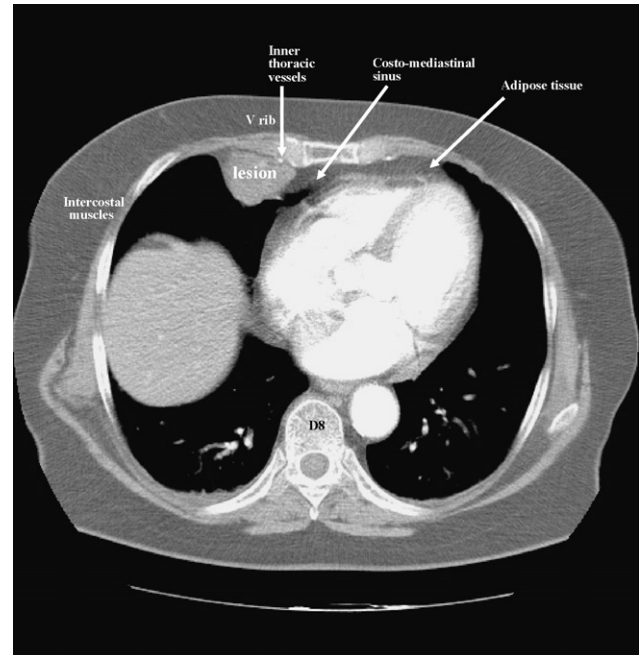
Leiomyosarcoma of the endothoracic fascia. Contrast-enhanced CT shows a mass with density characteristics indicating a soft bulky tissue. This mass is located at the level of the extrapleural antero-medial region of the right hemithorax, behind the internal mammary vessels, close to the costo-mediastinal sinus. Notice the position of the lesion in relation to the costo-mediastinal sinus.
